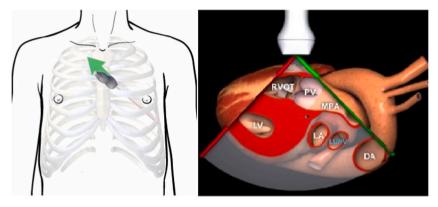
Parasternal long axis view: Right Ventricular Outflow Tract (Image reproduced with permission from http://pie.med.utoronto.ca/TTE).
